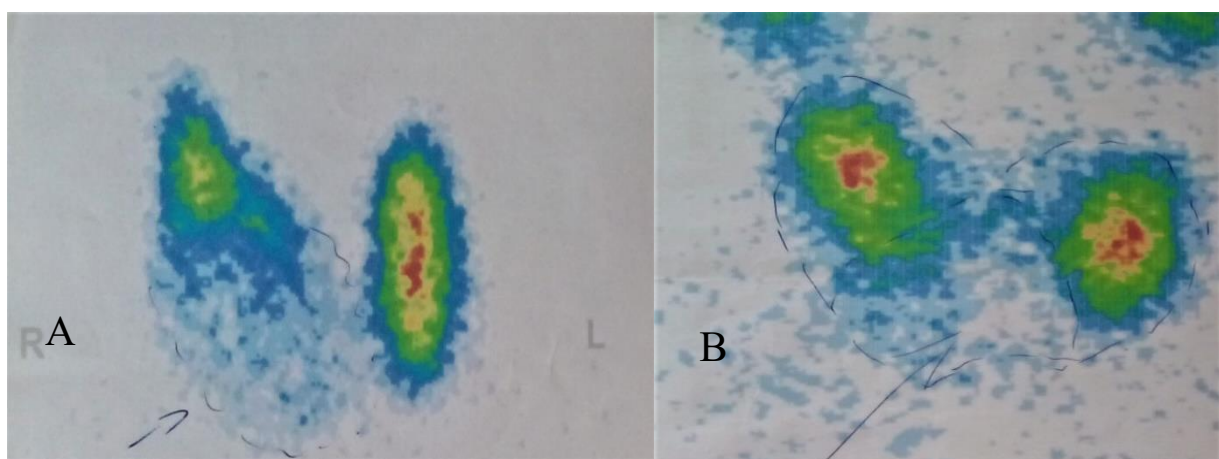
"Cold" scintigraphic thyroid nodules: A - right lobe nodule; B – nodule in the lower pole of the right lobe and the isthmus
